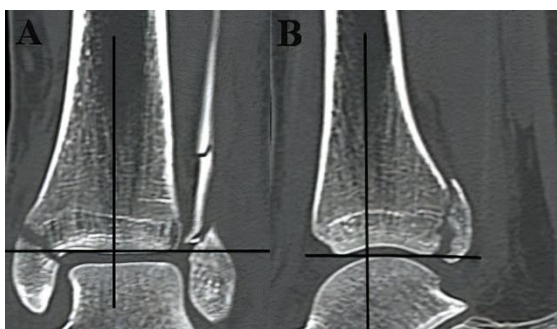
Reformatted CT to produce standardized, axial slices, A) transverse reference axis parallel to tibial plafond, B) longitudinal reference axis parallel to long axis of tibia.
